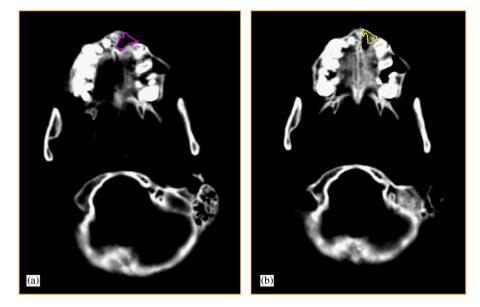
a, CT scan before bone grafting, b, at 1 year after bone grafting. The tracings depict the areas measured.
